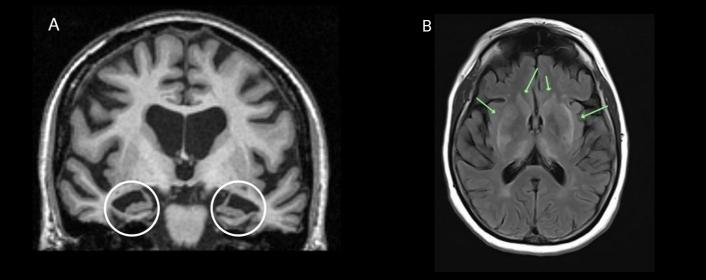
Coronal 2D slice from a 3D T1 weighted MRI (left) showing symmetrical medial temporal lobe atrophy (circled) in postmortem proven Alzheimer's disease [5]. T2- FLAIR MRI axial slice (right) showing the hyperintense abnormalities (arrows) that are the main pathological characteristic in Multiple Sclerosis [6]
